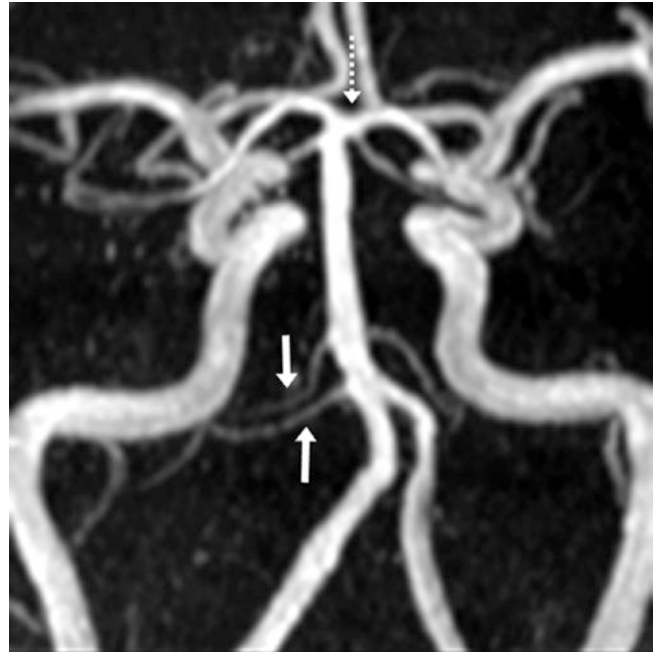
74-year-old with duplicated right AICAs (*arrows*) on 3D VR CTA PA views, and bilateral “fetal PCAs” (*dotted arrows*), which have corresponding hypoplastic P1 segments from the basilar artery
